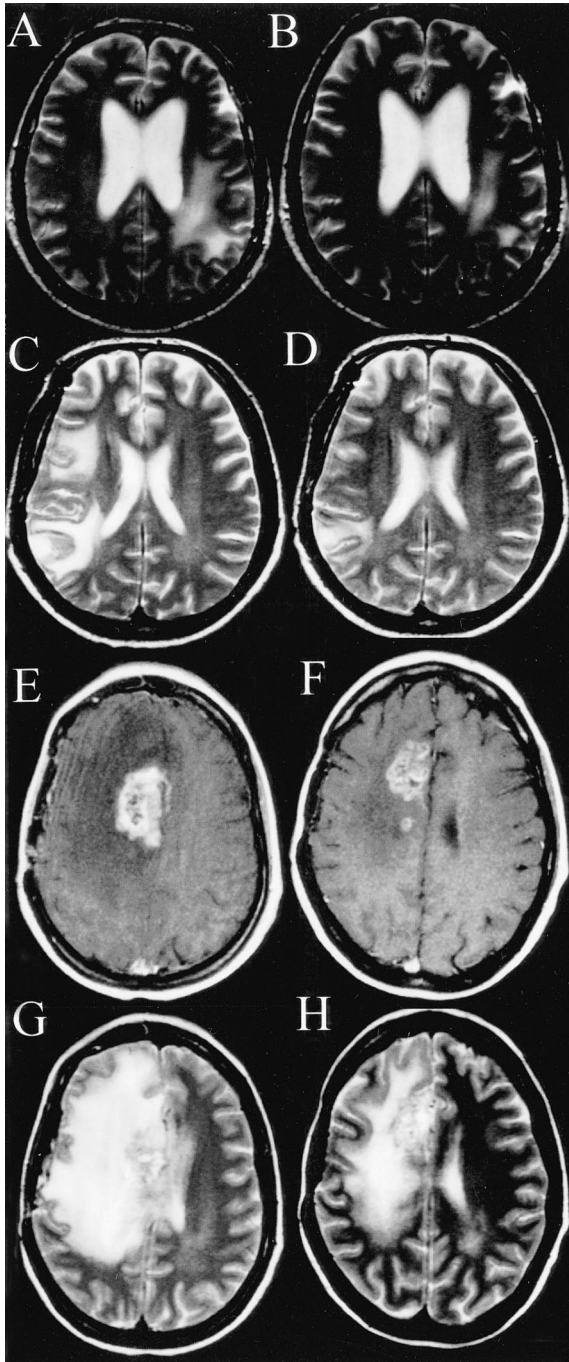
Radiologic responses to H15 in patients with brain tumors with progressive edema. (A and B) Patient 1 before and 1 week after initiation of H15 treatment (axial T2-weighted images). (C and D) Patient 5 before and 4 weeks after initiation of H15 treatment (axial T2-weighted images). (E through H) Patient 11 before and 4 weeks after initiation of H15 treatment; E and F are postcontrast axial T1-weighted images, and G and H show axial T2-weighted images.
